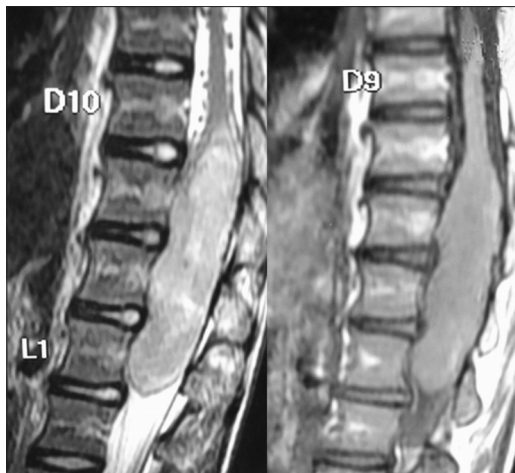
Magnetic resonance imaging showing intramedullary lesion
